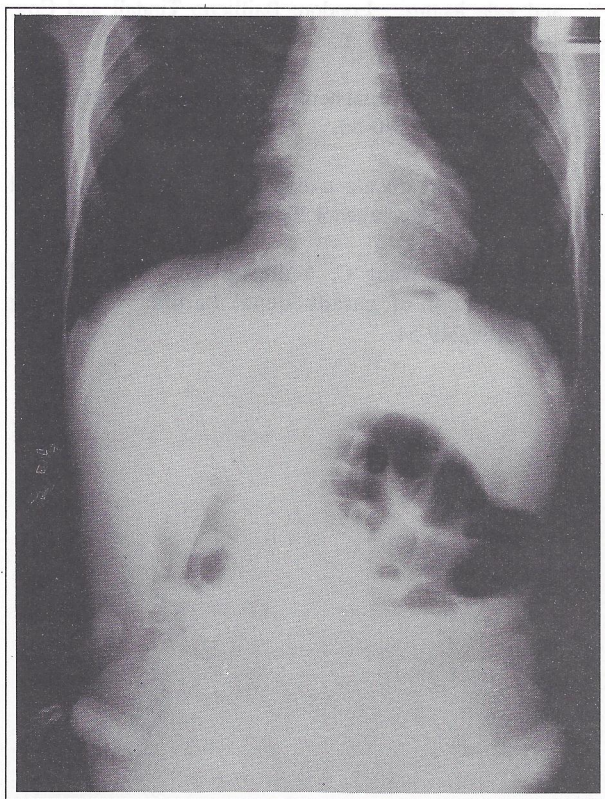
Plain supine X-ray of the abdomen showing dilated loops of small intestine confined to the left side of the abdomen.
